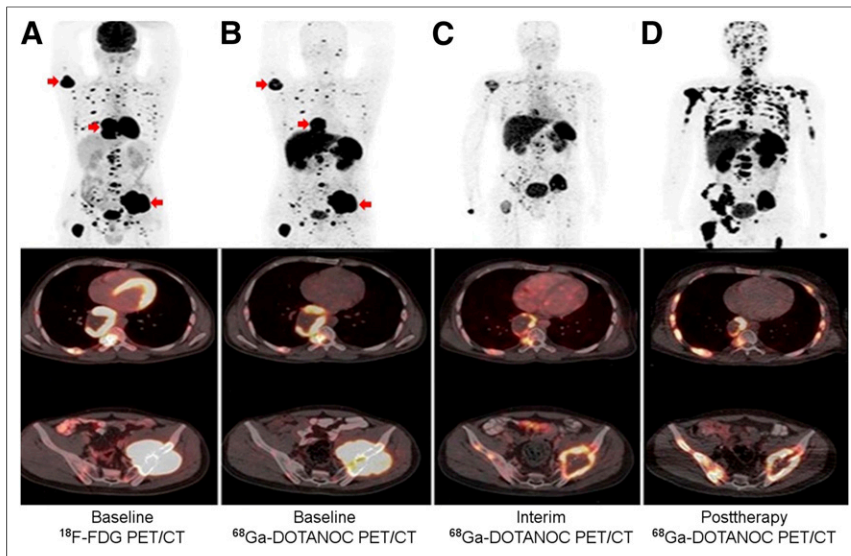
(A) Baseline ^{18}F -FDG PET/CT maximum-intensity-projection and transaxial fused images showed intensely tracer-avid (SUV_{max} , 40) right inferior mediastinal mass ($\sim 8.0 \times 5.2 \times 9.4$ cm), left iliac mass (SUV_{max} , 47.6), and widespread skeletal lesions. (B) Baseline ^{68}Ga -DOTANOC PET/CT showed intensely tracer-avid posterior mediastinal mass (SUV_{max} , 88) and multiple lytic skeletal lesions (left iliac bone SUV_{max} , 49.5). (C) Interim ^{68}Ga -DOTANOC PET/CT showed significant decrease in tracer avidity within lesions (SUV_{max} , 88–16.4 in mediastinal mass and 49.5–20.1 in left iliac bone/soft-tissue lesion) and concurrent decrease in size of lesions. (D) ^{68}Ga -DOTANOC PET/CT 2 mo after fourth cycle of peptide receptor chemoradionuclide therapy revealed disease progression.
